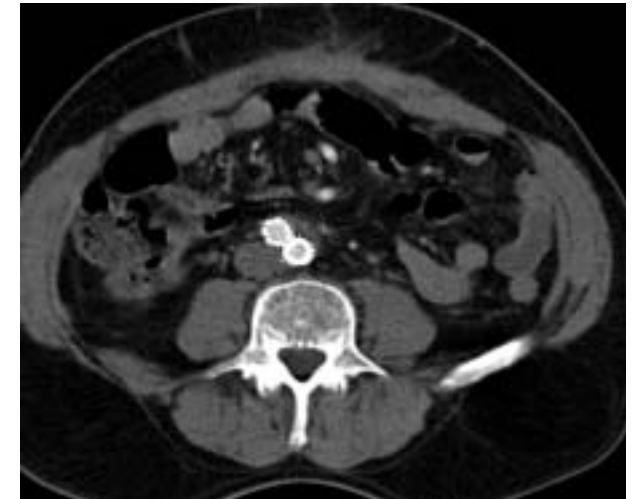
Surveillance CT at 6 years after successful ER showing nearly complete resolution of the aneurysm sac
